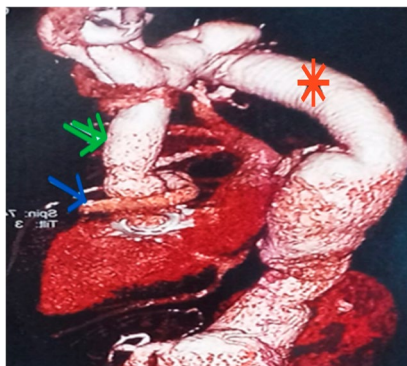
CT angiography of the Aorta reveals modified Cabrol tube graft (blue arrow), tube graft of Bentall procedure in ascending aorta position, hemiarch replacement (green arrows), and previous descending thoracic aorta tube graft (red asterisk).
